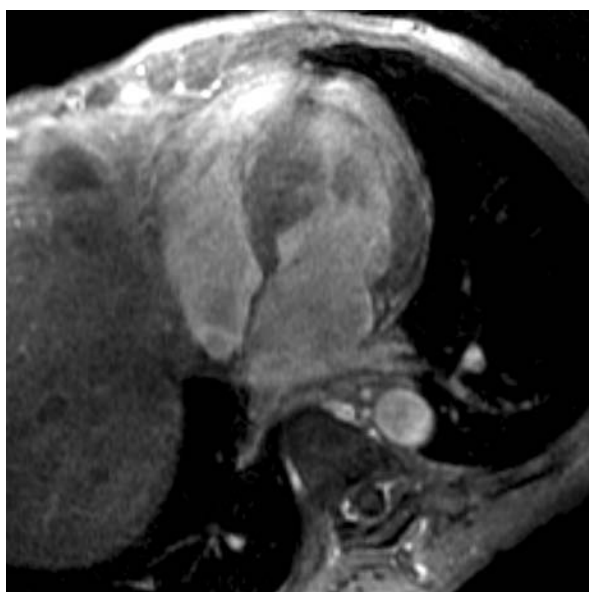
Magnetic resonance image (steady-state, free precession, horizontal long-axis view) shows a mass in the inferior basilar interventricular septum.
